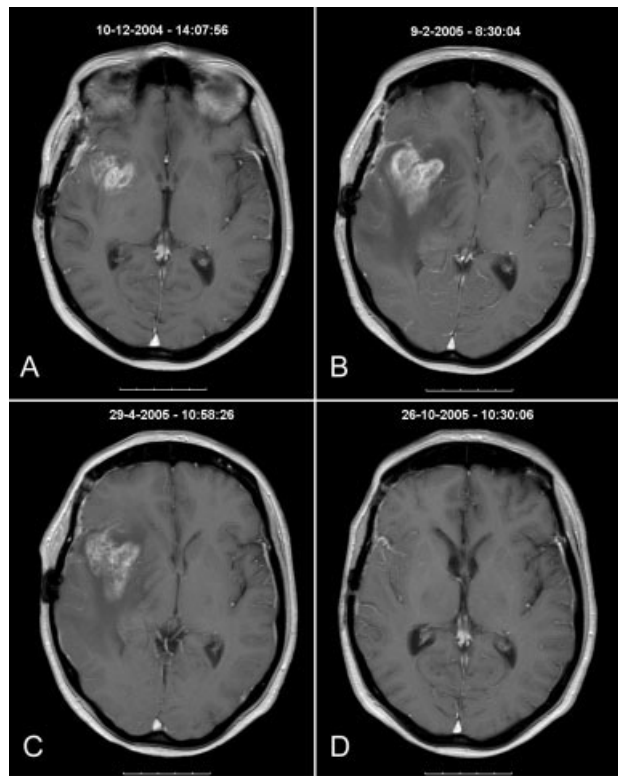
Patient 8 was a 50-year-old female who was diagnosed with a right temporal glioblastoma. Debulking surgery was followed by radiotherapy and concomitant temozolomide (RT/TMZ). Compared with (A) the pre-RT/TMZ scan, the (B) scan of the brain taken 4 weeks after RT/TMZ demonstrated disease progression within the area of gadolinium uptake. The patient remained clinically stable and was receiving a stable dose of dexamethasone. She continued with 3 cycles of adjuvant TMZ and the dexamethasone dose was gradually lowered and withdrawn. (C) The magnetic resonance imaging (MRI) scan taken 3 months after RT/TMZ was unchanged and she received another 3 cycles of TMZ. (D) The MRI scans taken 6 months and 9 months, respectively, after RT/TMZ demonstrated a diminishing lesion. The patient developed disease progression 12 months after RT/TMZ.
